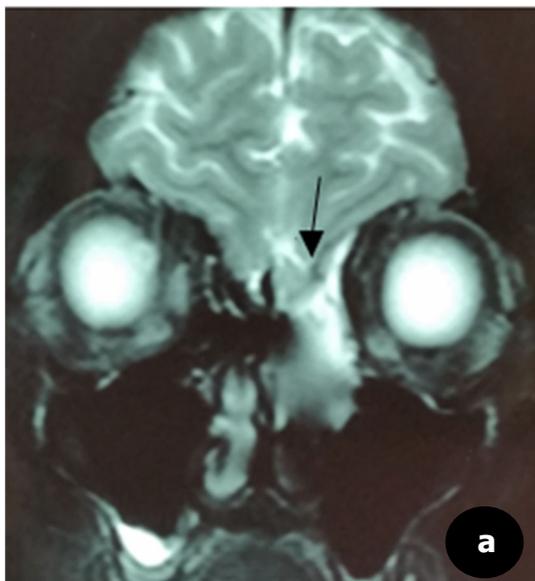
MRI (Coronal T2) of the head
